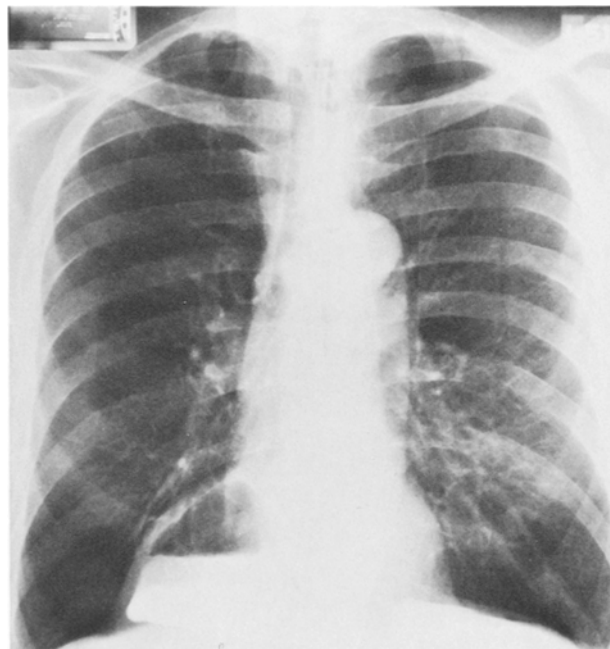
Chest x-ray showing an air-fluid level in a large epigastric diverticulum. Retained barium from an earlier upper gastrointestinal tract series is present. Typically, the diverticulum protrudes to the right.
